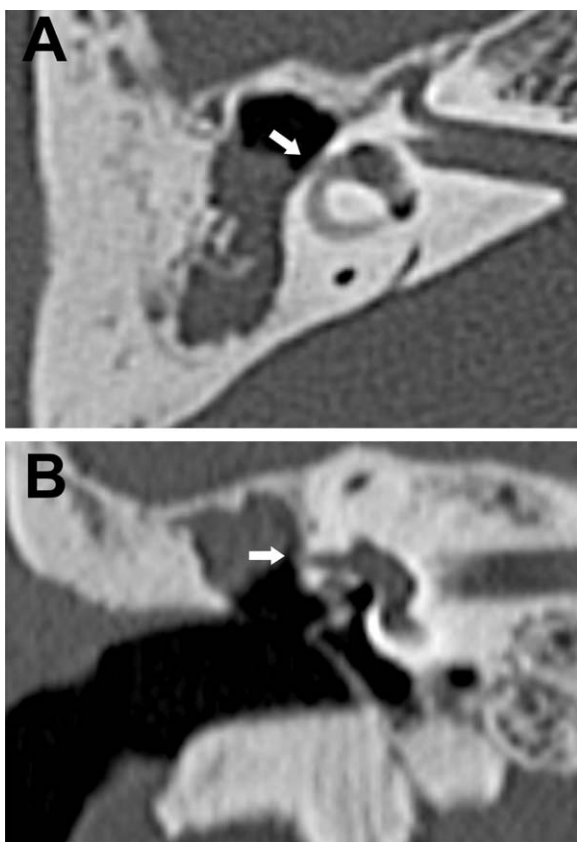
Axial (A) and coronal (B) computed tomography scans showing a cholesteatoma with destruction of the temporal bone and a labyrinthine fistula of the lateral semicircular canal of the right ear (white arrow).
